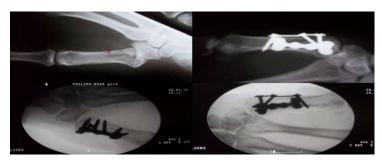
includes preoperative, and postoperative xray And IITV images intraoperatively.
